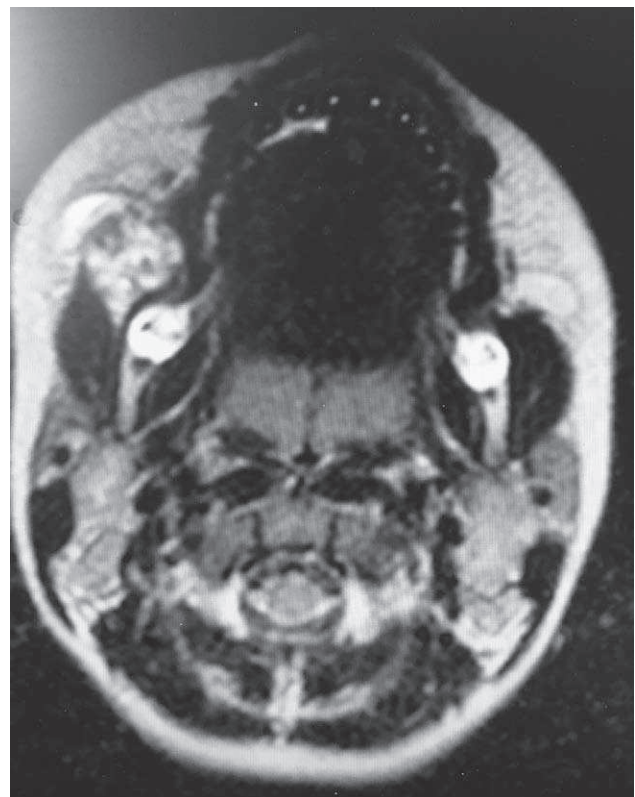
MRI reveals a relatively well-circumscribed lesion on the muscle, with post contrast prominent enhancement on T1WI and peripheral rim of fatty signal well-visualized on T1WI sequences.
